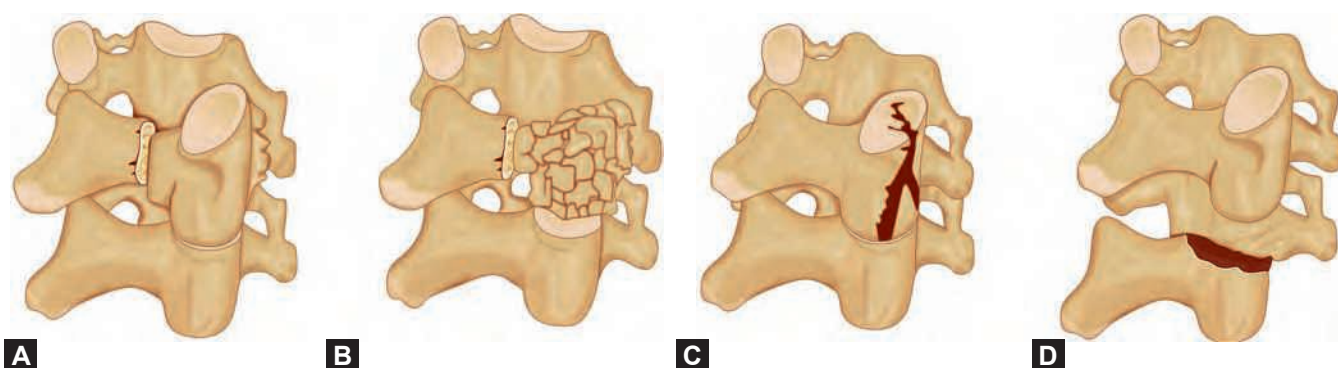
to E: Computed tomographic image of a bilateral C6/7 dislocation.
